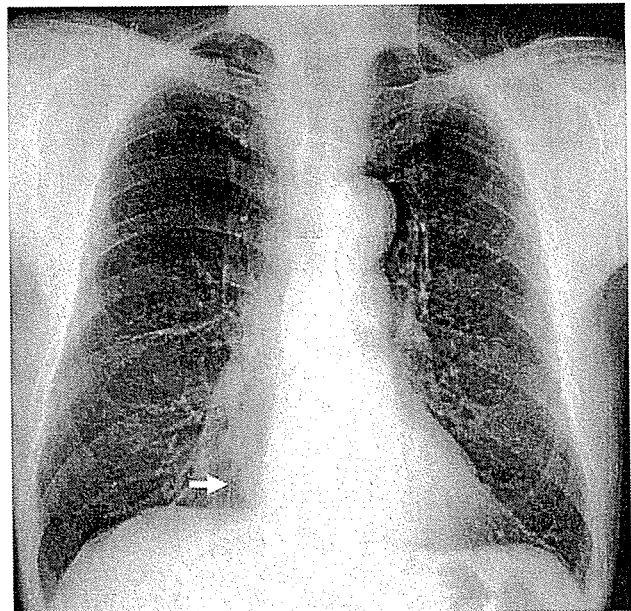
Chest X-ray reveals a right cardiophrenic angle mass (arrow)
